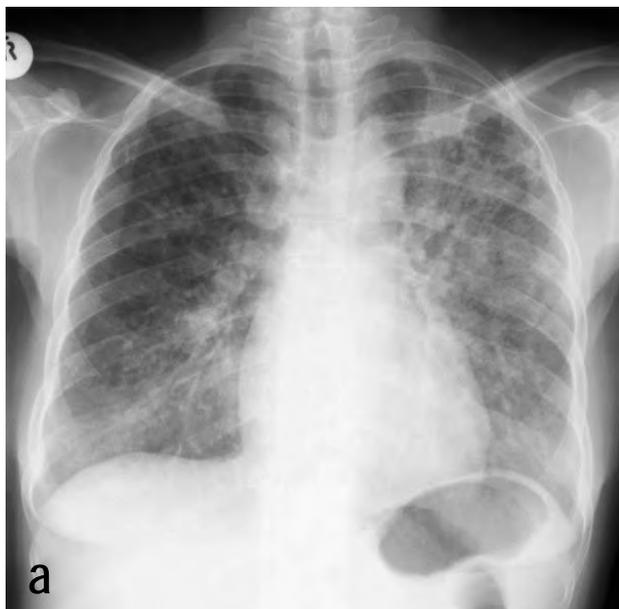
c. In the chest radiographs of patients 2, 3 and 4, nonspecific bilateral reticular-nodular and ground-glass opacities were present with no features of an effusion.
